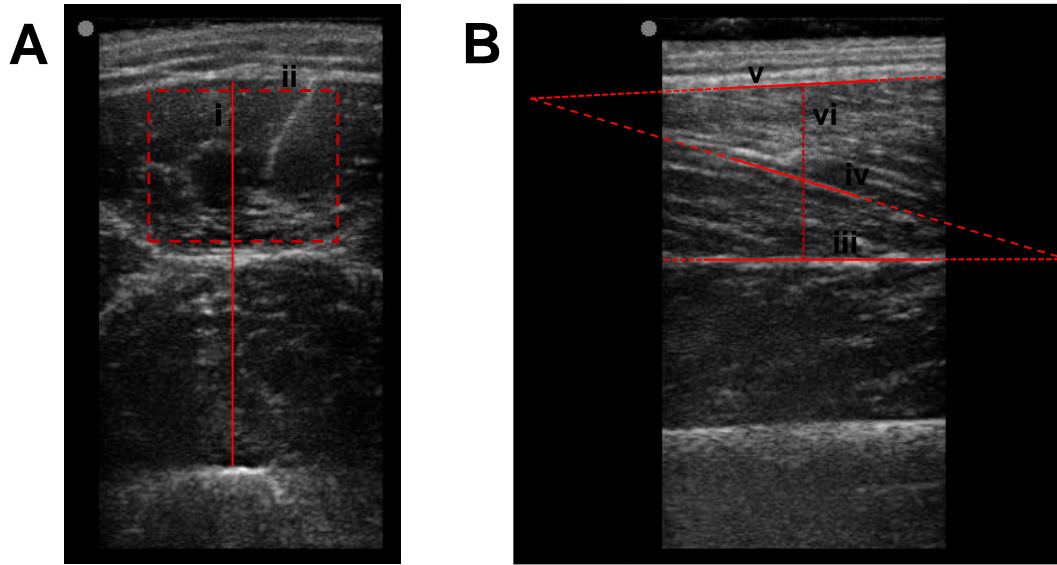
Segmentation of ultrasound images to determine (A) muscle thickness and echogenicity, and (B) pennation angle and fascicle length.
